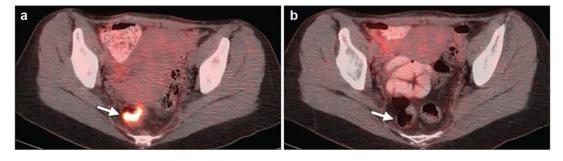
[¹⁸F]FDG PET/CT for initial staging and assessment of response to neoadjuvant therapy in 40-year-old woman with rectal adenocarcinoma. (a) Axial-fused PET/CT image obtained for initial staging shows metabolically active (standardized uptake value, 6.8) mass (*arrow*) in rectal wall. (b) Axial [¹⁸F]FDG-PET/CT image obtained 3 months after staging PET/CT study (a) and after patient
